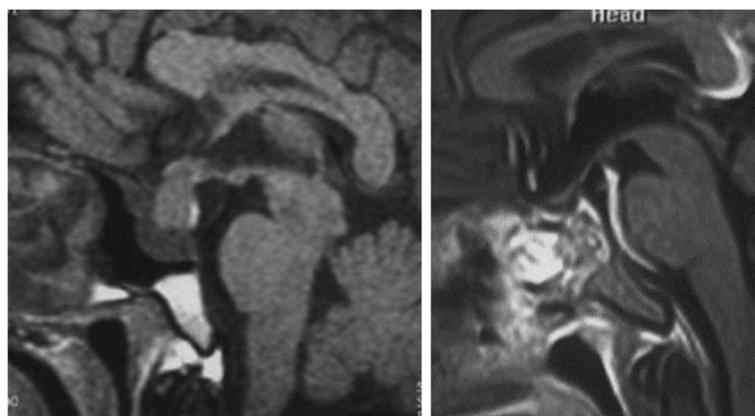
T1-weighted sagittal (left) and with contrast (right) MRI demonstrated the sel-lar/suprasellar mass lesion was disappeared 3 months after surgery
